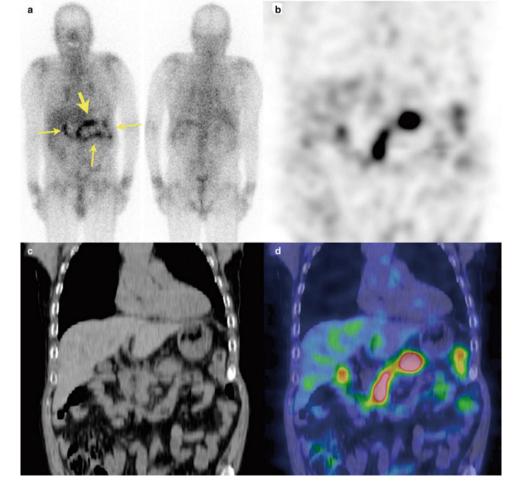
Detection of pancreatic lesions by whole-body 67 Ga scintigraphy (a) and SPECT (b-d). On coronal section fusion image (d), clear accumulation in the pancreas is seen
